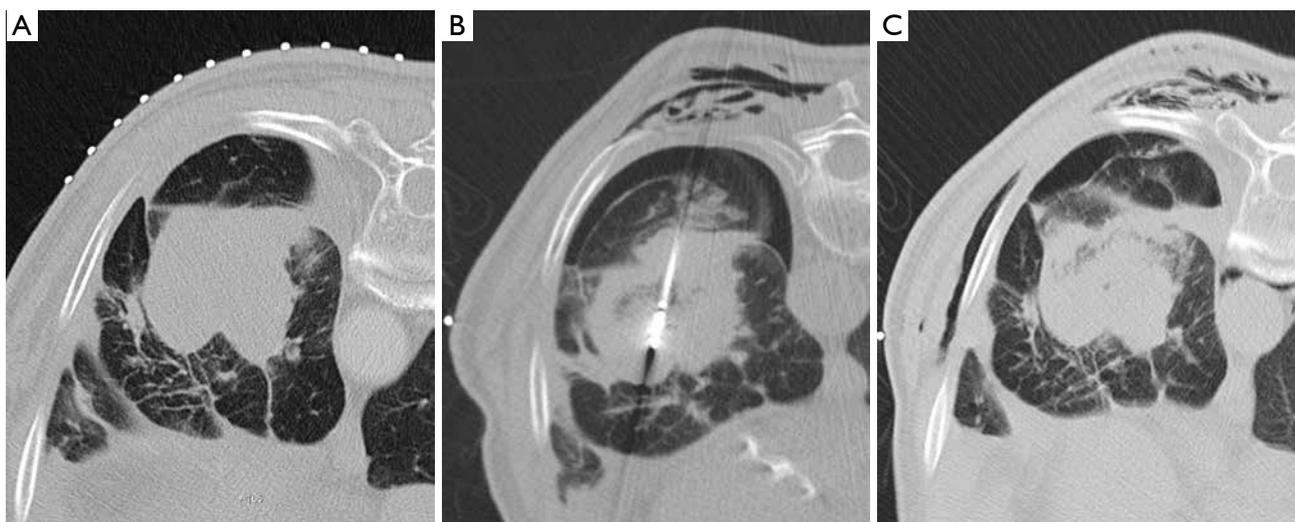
A 72-year-old man with incomplete response to external beam radiation to left lower lobe NSCLC, who presented for salvage MWA. He had an intractable cough throughout the procedure. (A) Prone axial CT image shows a 5.5 cm mass before MWA; (B) prone axial CT during the procedure shows a small pneumothorax and surgical emphysema developing around the antenna entry site; (C) prone axial CT at the end of the procedure shows the pneumothorax has remained similar in size, but there is increased surgical emphysema.
